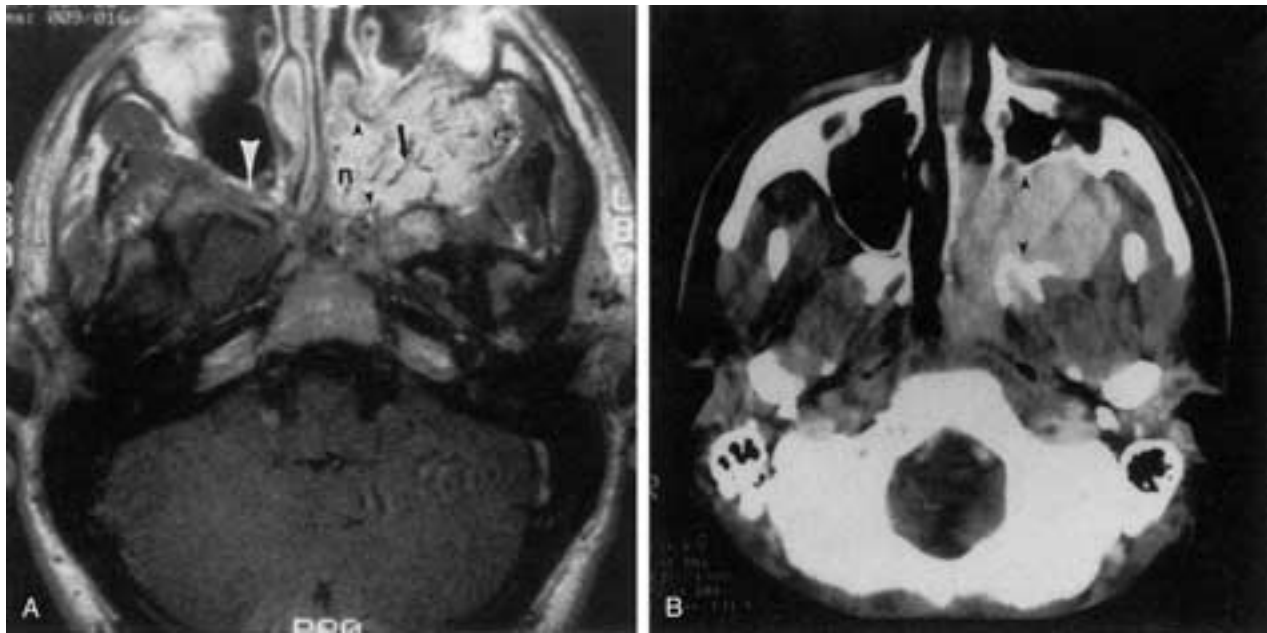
A, Juvenile angiofibroma expanding the pterygopalatine fossa. The T1-weighted postgadolinium MR image shows enhancing tumor in the region of the pterygopalatine fossa. It expands laterally (*open arrow*) into the infratemporal fossa, and medially the tumor passes through the region of the sphenopalatine foramen (*small black arrowheads*) into the posterior nasal cavity (*n*) and nasopharynx. Compare this with the normal pterygopalatine fossa (*white arrowhead*) on the opposite side. Flow voids representing large vessels (*black arrow*) can be seen within the tumor. B, CT scan shows the enlargement of the pterygopalatine fossa (*small black arrowheads*) by the enhancing mass. There is remodeling of the posterior wall of the maxillary sinus anteriorly. The pterygoid plates are pushed slightly posteriorly.
